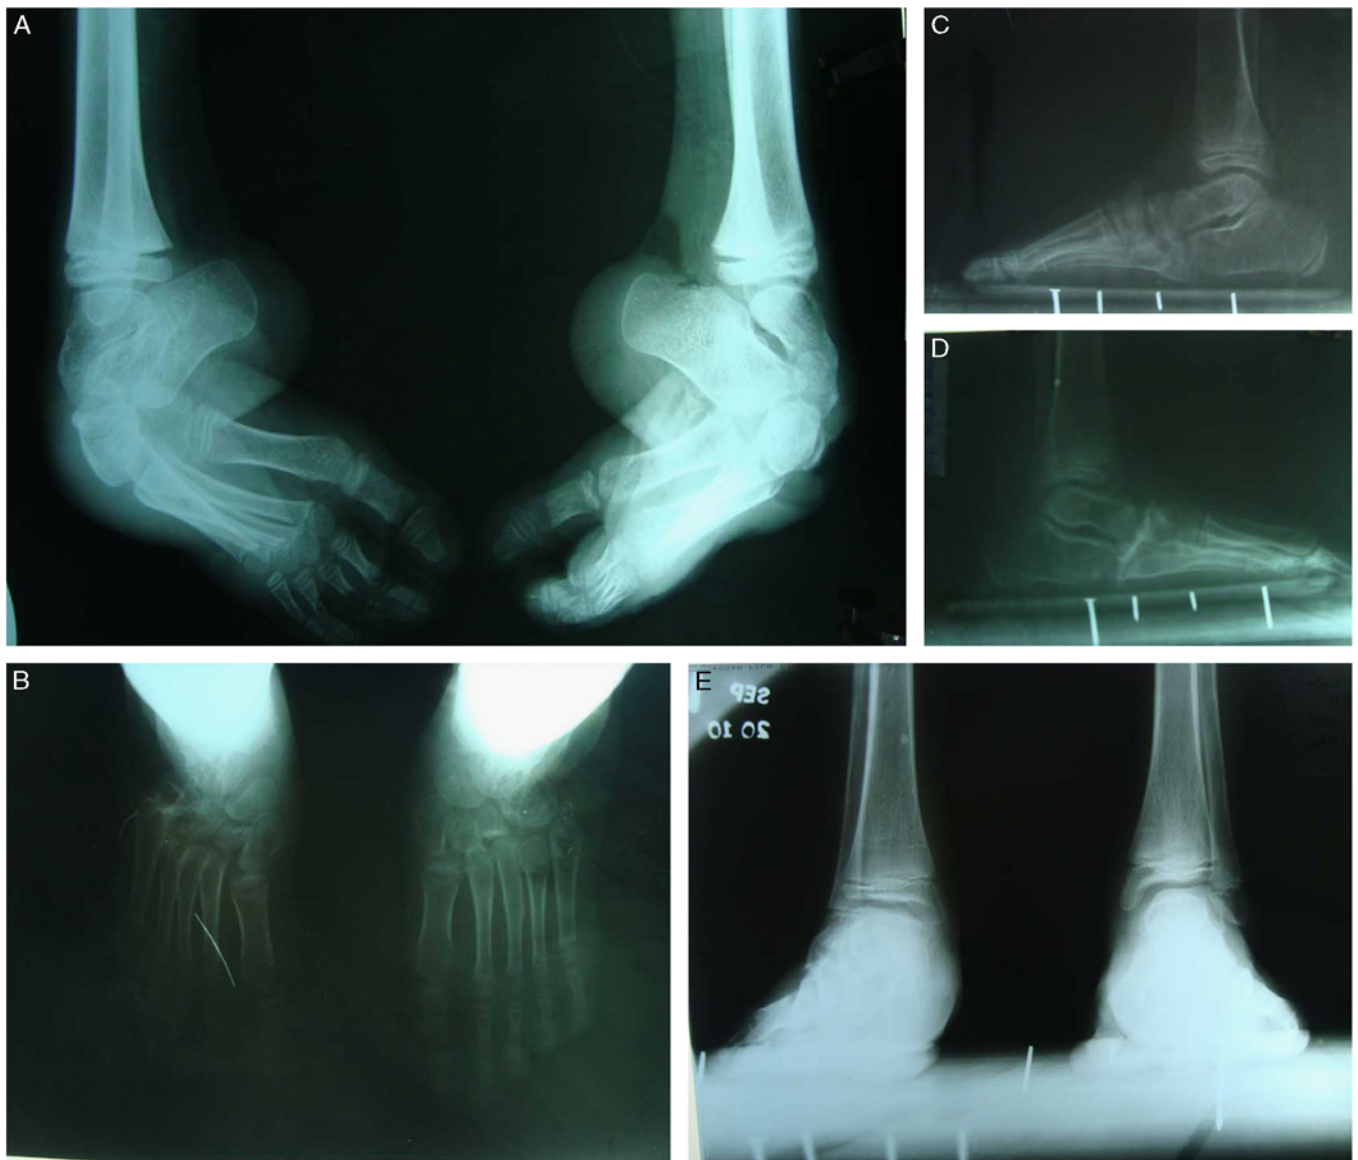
(A) Preoperative radiograph suggesting severe bony deformation. (B) Postoperative, standing anteroposterior radiograph suggesting good union at the osteotomy site and restoration of the bony relationship to a great extent, but it is not anatomical. (C) Postoperative standing lateral radiograph left-side. (D) Postoperative standing lateral radiograph right-side. (E) Postoperative ankle, standing anteroposterior view suggesting near normal ankle joints for both feet.
